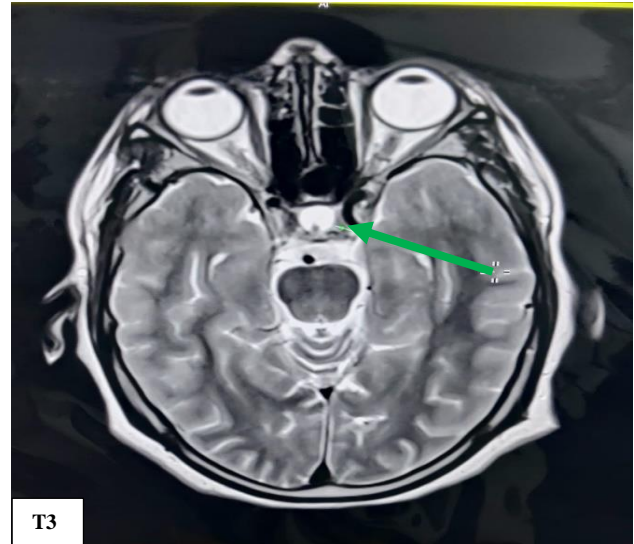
T3-cronal T3-Weighted MRI image green arrow located a presence of empty Sella.
